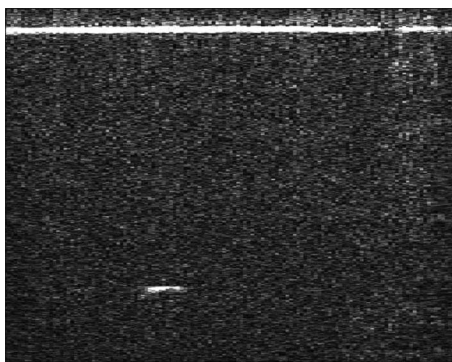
In vivo* PA and US B-scan imaging of an SLN dyed with ICG and guiding of a biopsy needle: (a) control PA image acquired before ICG injection, (b) PA image taken 10 min after ICG injection, (c) overlaid PA (pseudocolor) and US (gray scale) images, (d) US guidance of a biopsy needle, and (e) PA guidance of a biopsy needle. The image contrasts were calculated using the values within the regions of interest indicated by the yellow dotted boxes in (d) and (e). PA, photoacoustic; US, ultrasound; ICG, indocyanine green; and SLN, sentinel lymph node. (Color online only.)
